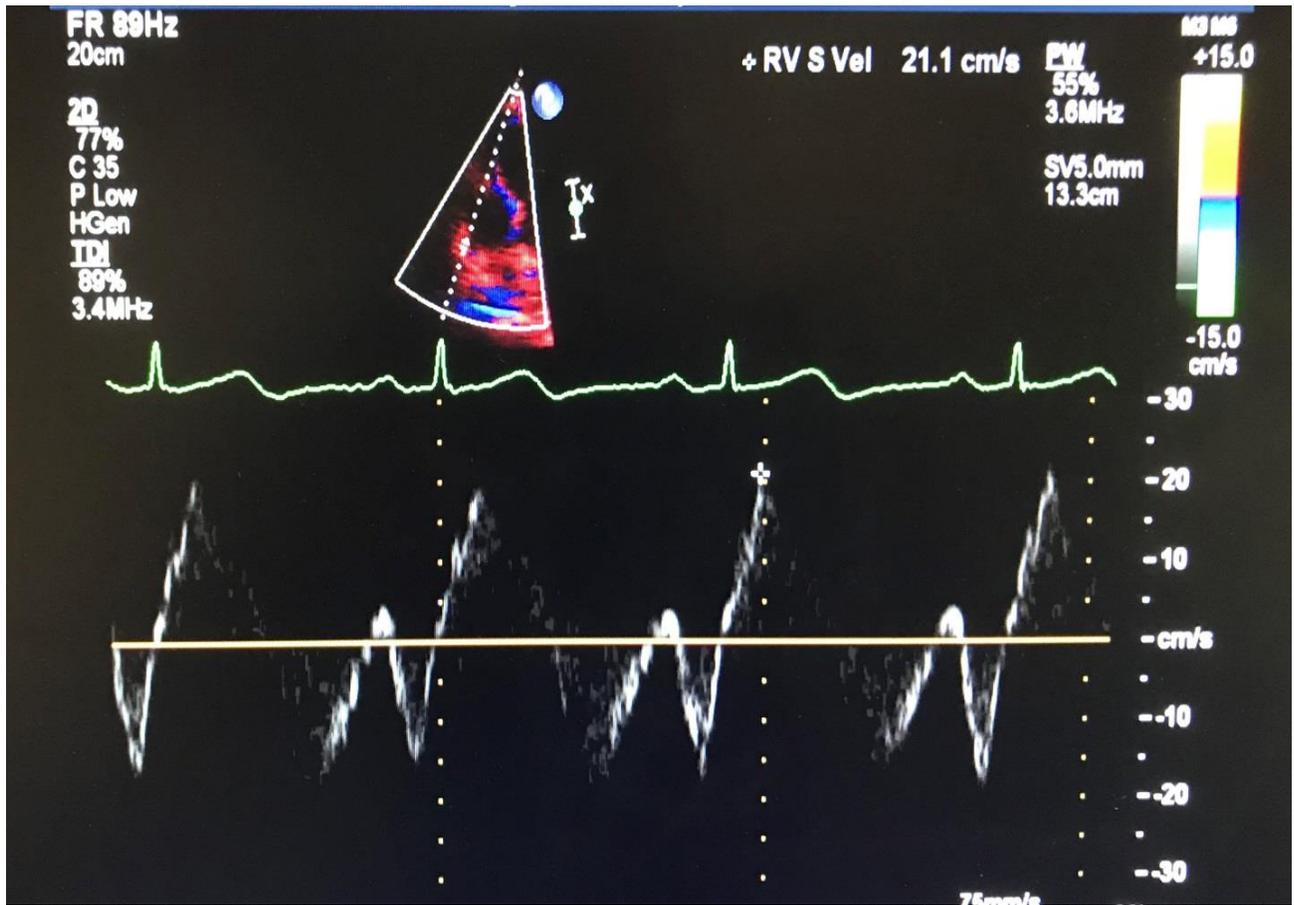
Tissue Doppler imaging of RV during rest.
